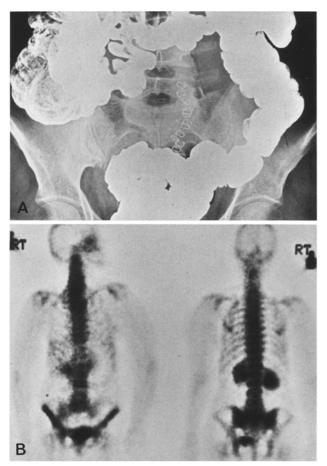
Deficiency in isotope activity on anteroposterior scan resulting from overlying barium-filled colon. A Radiograph shows residual barium from gastrointestinal tract examination on previous day. B Anterior view shows photopenic foci in lumbar spine, but posterior view, with barium-filled colon no longer interposed between spine and detector, reveals normal activity
